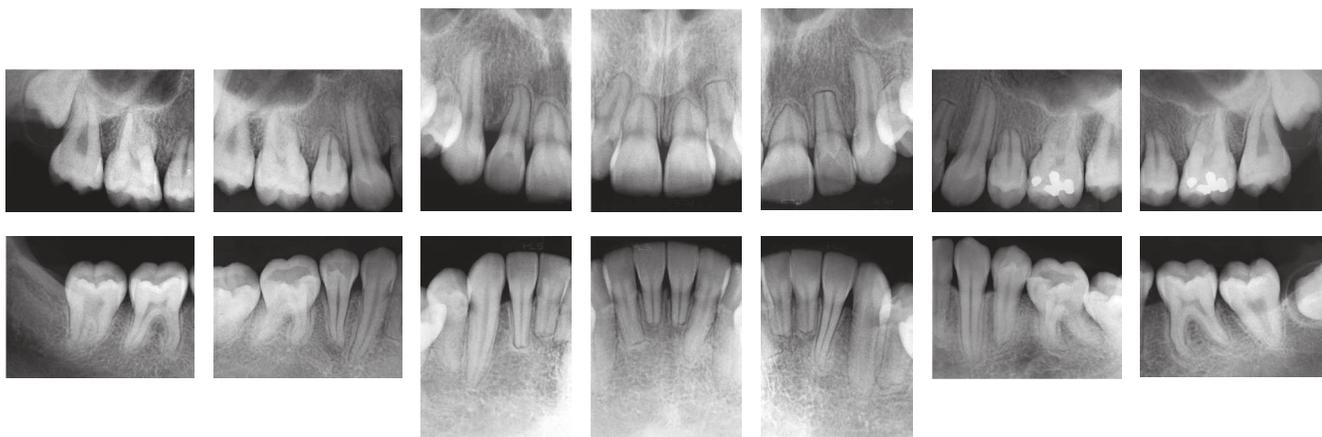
Final intraoral (periapical) radiographs.
